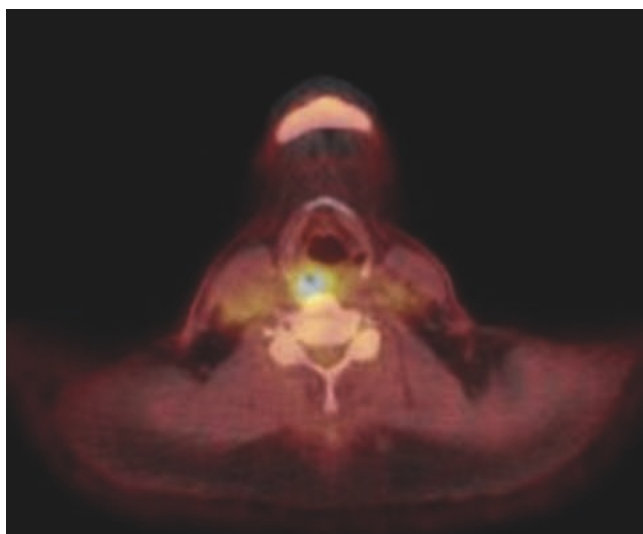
Axial view positron emission tomography-computed tomography demonstrating positron emission tomography-avid soft tissue lesion overlying the right arytaenoid cartilage.
